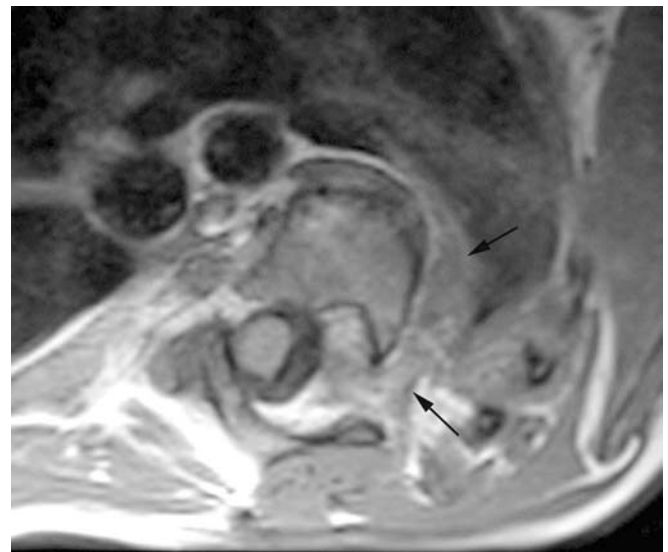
Axial T1W MRI through the upper thoracic spine demonstrating plexiform neurofibromatous tissue (*arrows*) around the vertebral body, entering the left intervertebral foramen and associated with posterior vertebral scalloping
